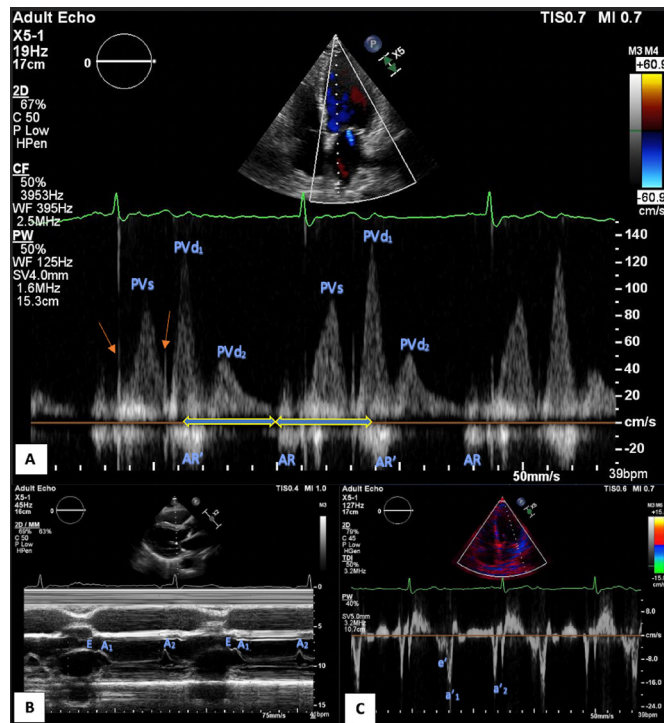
(A) Pulmonary vein pulsed wave Doppler pattern showing normal PVs and AR waves with an abnormal biphasic diastolic wave (PVd₁ and PVd₂). PVd₁ corresponds to a non-conducted P wave on the electrogram. The cycle length between P waves is about 730 ms. Mitral and aortic valve closure clicks are shown (orange arrows). (B) Mitral valve M-mode showing the opening of the mitral valve with both the non-conducted P wave (A₁) as well as the conducted P wave (A₂). (C) Lateral mitral annular tissue Doppler annular motion due to the extra atrial contraction (a₁) in early diastole and normal atrial contraction (a₂). AR, atrial systolic reversal wave; AR', atrial systolic reversal wave from extra atrial contraction; PVd, pulmonary vein diastolic wave; PVs, pulmonary vein systolic wave.
